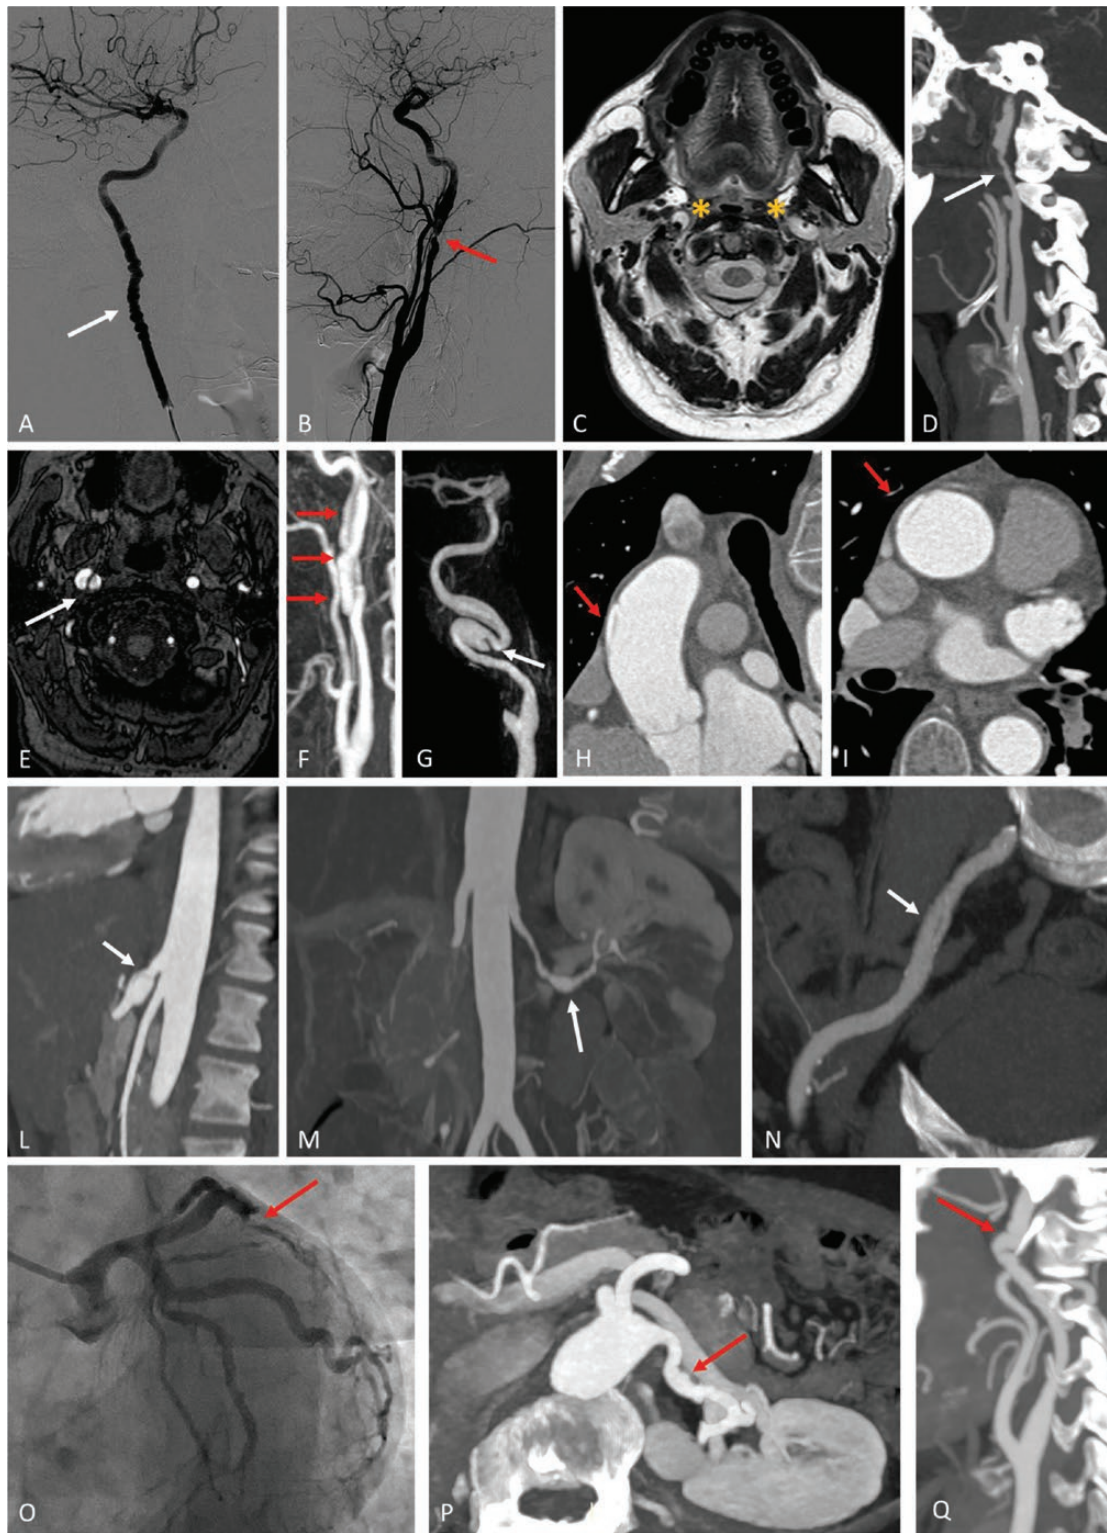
Examples of arterial dissection in patients with FMD. (a and b) Digital subtraction angiography of the right internal carotid artery (ICA) (white arrow) (a) and left carotid axis (b) showing the typical string of beads appearance in (a) and the angiographic appearance of ICA dissection with a severe, irregular stenosis followed by a dilated segment (red arrow) (same patient in a and b). (c and d) Acute bilateral ICA dissection with the mural hematoma as hyperintense crescent sign within the wall of ICA in axial T2W DIXON sequence (yellow asterisk) (c) and the corresponding CTA with Maximum Intensity Projections (MIP) reconstructions of the right ICA, showing a long, irregular stenosis in the dissected segment (white arrow) (d). (e and f) MRA with right ICA intimal flap and double lumen (white arrow) (e) and the corresponding CE-MRA reconstruction of the dissected segment with a spiroid pattern and enlargement of vessel caliber (red arrows) (f). (g) Tridimensional reconstruction (CE-MRA) of an ICA dissecting aneurysm with a persistent intimal flap (white arrow). (h and i) CTA with focal aortic dissection in a patient with FMD (sagittal and axial planes in h and i, respectively) (red arrows). (j) Celiac trunk dissection with aneurysm (MIP reconstructed CTA) (white arrow). (k) Left renal artery dissection with irregular severe tubular stenosis, followed by an aneurysm and persistent occlusion of left inferior polar artery with renal infarction (MIP reconstructed CTA) (white arrow). (l) Right common iliac artery dissection with an intraluminal flap (MIP reconstructed CTA) as incidental finding in the follow-up of a patient with FMD patient (white arrow). (o-q) Same patient with a left coronary artery dissection (o), a left renal artery multifocal FMD lesion (p) and a right ICA string of beads pattern (q) (red arrows).
